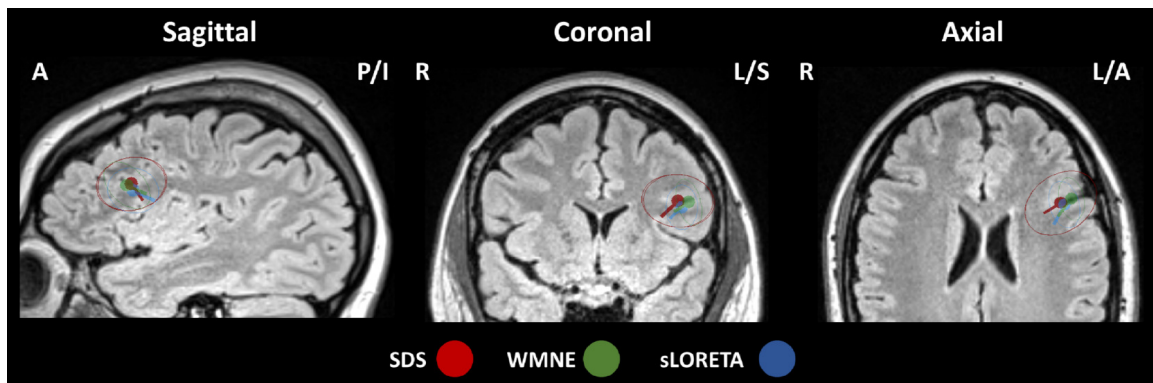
Comparison of difference inverse methods: Spike cluster centroids and spread ellipsoids for SDS (in red), WMNE (in green) and sLORETA (in blue) are depicted on the FLAIR MRI at the spike onset. The centroid dipoles are presented for the EMEG modality while the most detailed head model 6CAH_Cal was used. The SDS centroid locations were used for the selection of MRI slices. The dipole size was kept constant for all the dipoles. Anterior (A), Posterior (P), Inferior (I), Left (L) and Right (R) show MRI orientation.
